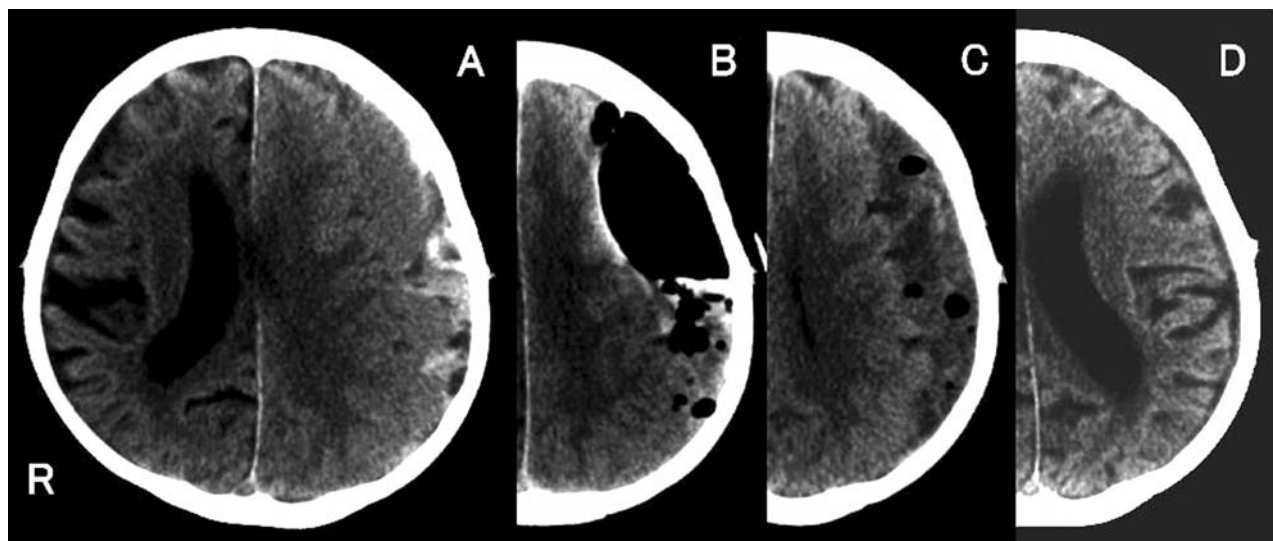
Atypical progress. (A) Irregular density hematoma was revealed on the left side in the CT scan. (B) The hematoma remains considerable and existence of some cavities was also suspected. (C) Ten days after surgery. Although no neurological deficit was found, the hematoma has increased. (D) Sixty days after surgery without re-operation, no hematoma was found
